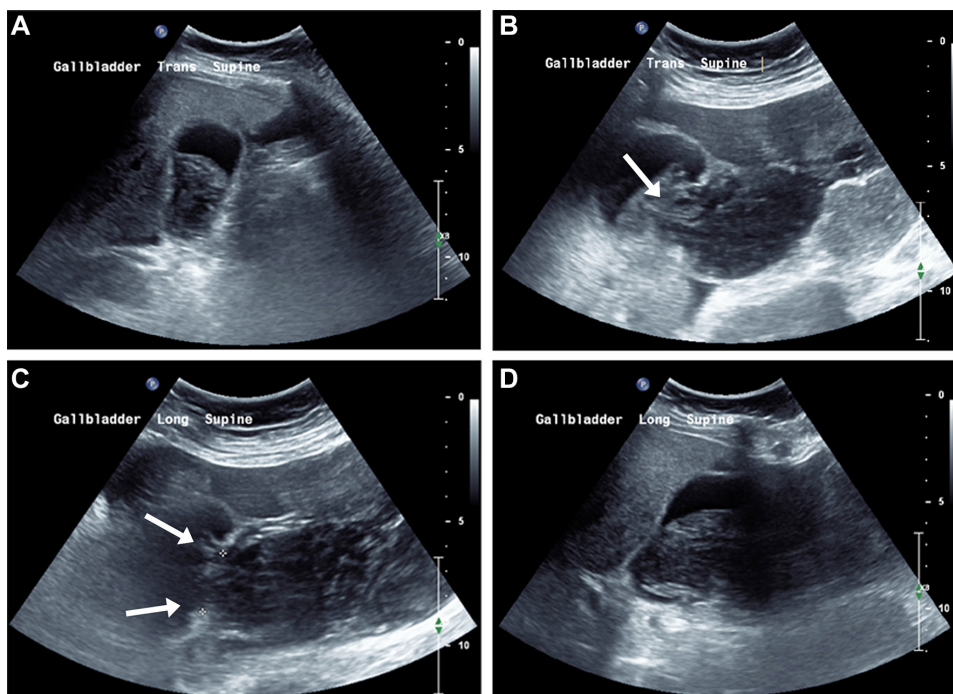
(A–D) Targeted upper abdominal ultrasound demonstrating contiguous haemobilium and haemoperitoneum, across a defect within the gallbladder fundus (arrows).
